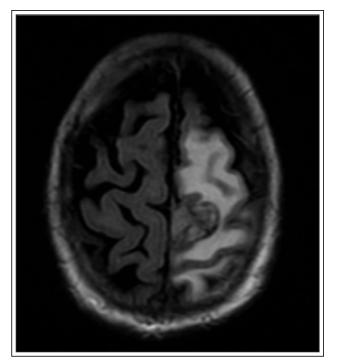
Axial flair T2 MRI.
